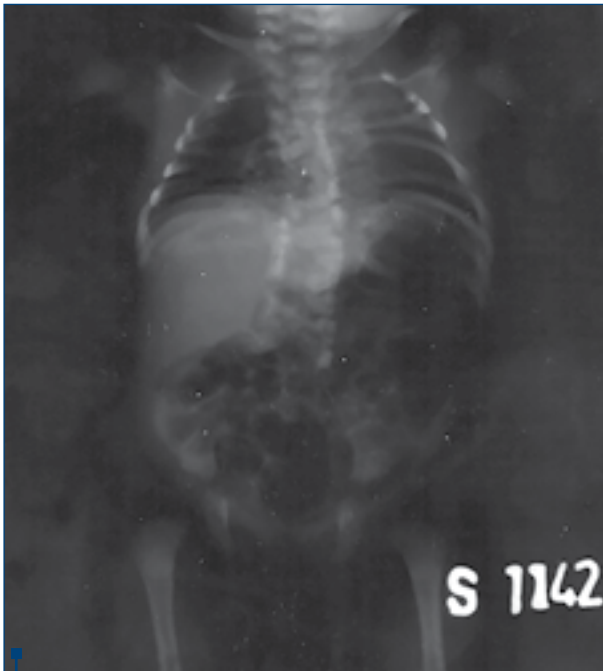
Postnatal X-Ray - abnormal shape of the spine and abnormal rib cage (small thorax)
